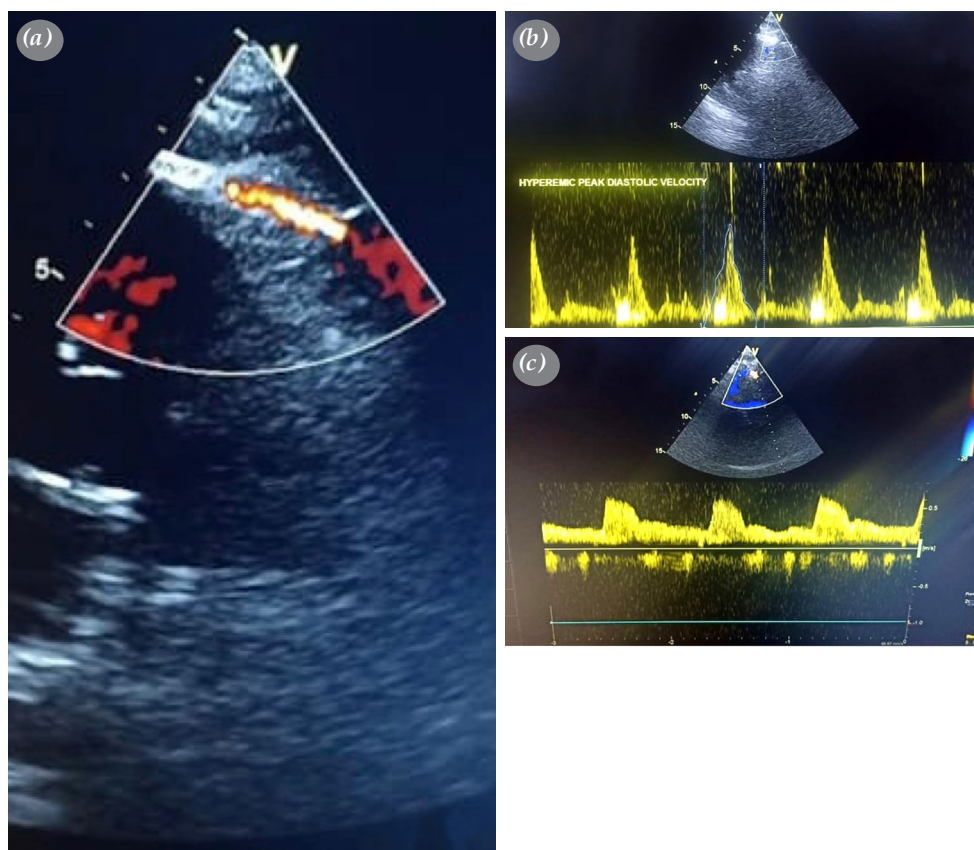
(a) Coronary flow reserve measurements were performed with apical two-chamber long-axis imaging of left ventricle. Middle and distal LAD flow was visualized by color Doppler with an optimal velocity of 12 to 15 cm/sec. Coronary flow of middle or distal LAD was examined over the epicardial part of the anterior left ventricular wall by color Doppler flow mapping. (b) Transthoracic echocardiographic images of a control group patient. Hyperemic diastolic flow was measured by pulsed-wave Doppler in distal LAD segment. (c) Transthoracic echocardiographic images of an FM patient. Hyperemic diastolic flow was measured by pulsed-wave Doppler in distal LAD segment.
